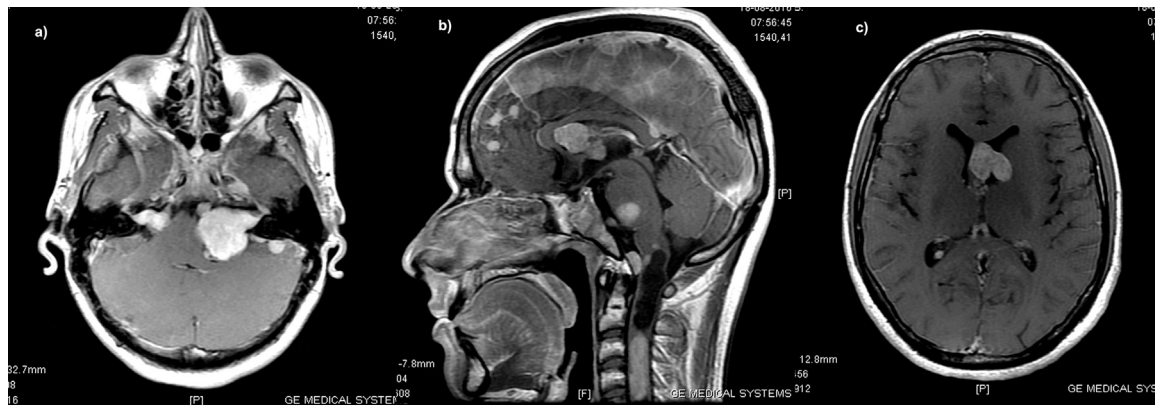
(a) Axial contrast-enhanced T1WI MRI showing bilateral VIII nerve schwannomas with “ice cream cone” appearance. (b) Sagittal contrast-enhanced T1WI MRI showing multiple enhancing meningiomas arising from the falx cerebri. (c) Axial contrast-enhanced T1WI MRI showing ependymoma in the left lateral ventricle.
